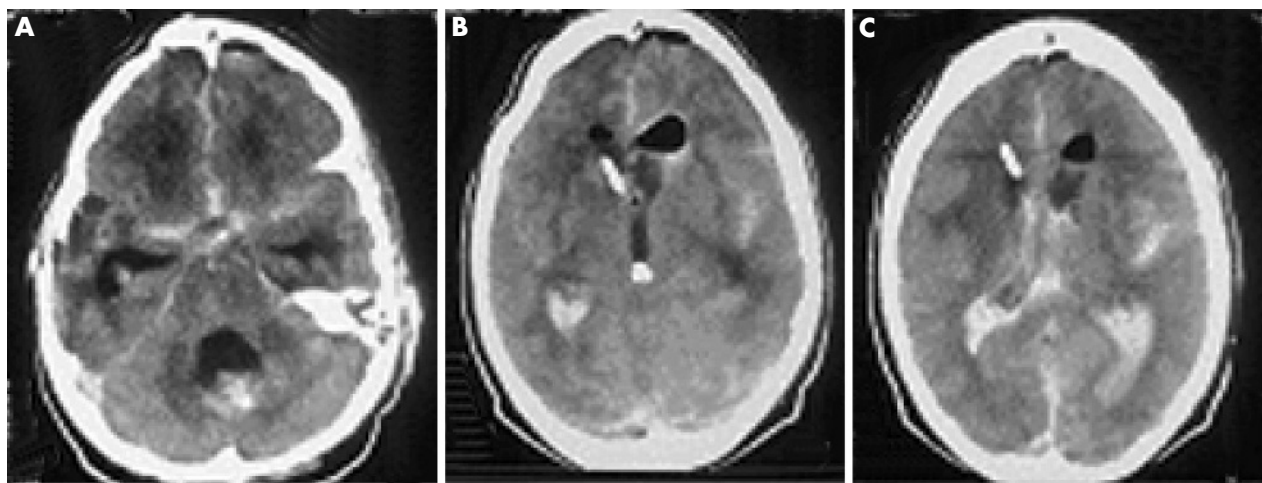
Immediate postoperative computed tomography scan: the fourth and third ventricles are completely free of blood (A, B); a residue of blood in the lateral ventricles (C), which is not considered crucial for circulation of cerebrospinal fluid (patient 6).
